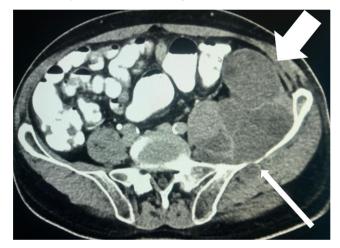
Septal cystic mass (thick white arrow) that erodes the bone structure within the iliacus muscle (thin white arrow) on axial CT
